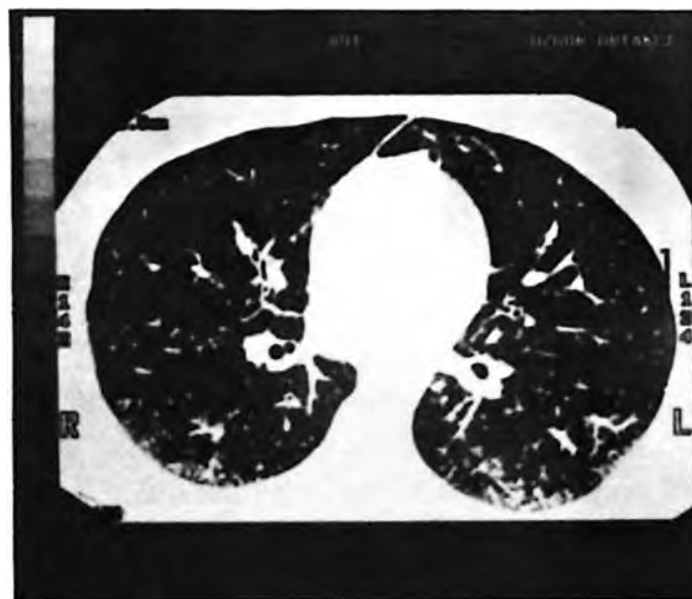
HRCT findings are definitely seen as small reticular patterns in the lower lobes related with fibrosis.
